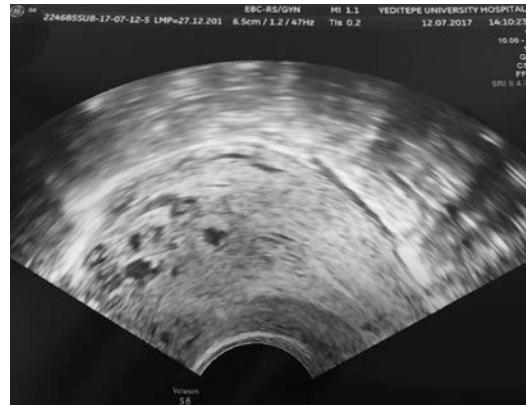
A “pseudo sac” could be seen by transvaginal ultrasound
